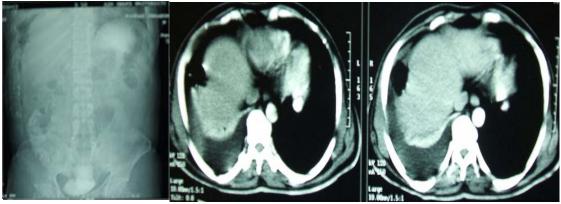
A) CT scan lower chest and upper abdomen (scout view) showing air in right side of abdomen due to duodenal injury. B) The same patient air and fluid collection due to duodenal injury.
